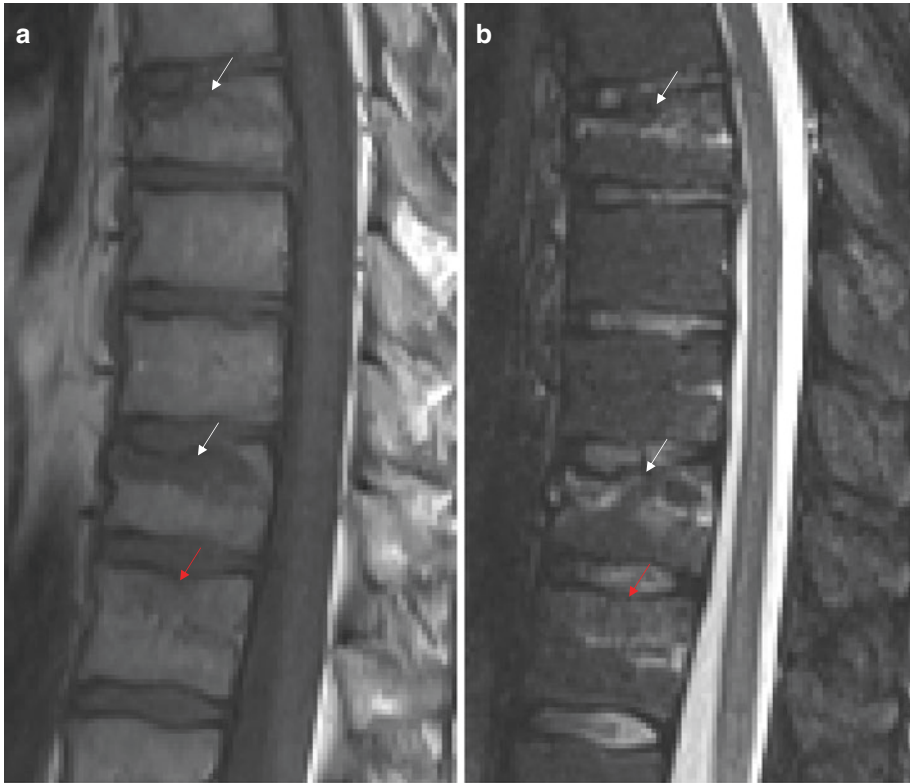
(a) Sagittal T1-weighted image demonstrates hypointense bands or lines traversing the T8 and T11 vertebral bodies beneath the superior endplates compatible with wedge compression fractures (white arrows). (b) Corresponding sagittal
